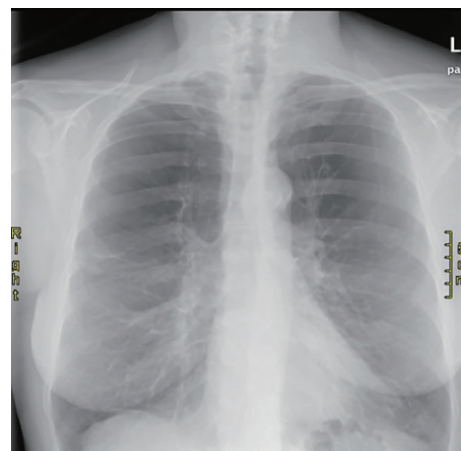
Frontal chest radiographs. a) Pre-procedural radiograph with severe emphysematous upper lobes. b) Complete collapse of the left upper lobe (white arrow) at two weeks after EBV placement. Elevated left dome of diaphragm secondary to volume loss (black arrow).
